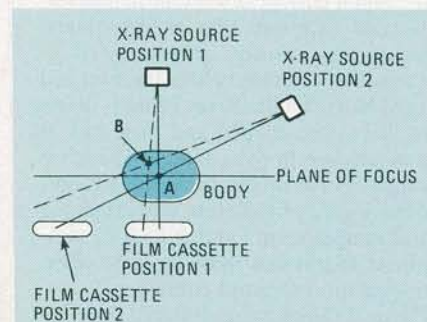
CONVENTIONAL TOMOGRAPHY. In this technique, the X-ray source and the film cassette move in such a way as to keep all the structures in one plane in focus.
